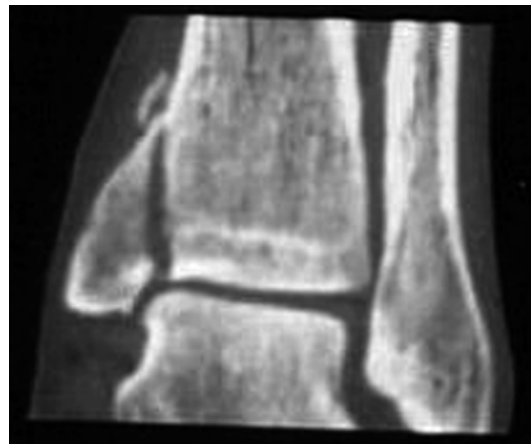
CT scan showing a displaced stress fracture of medial malleolus
